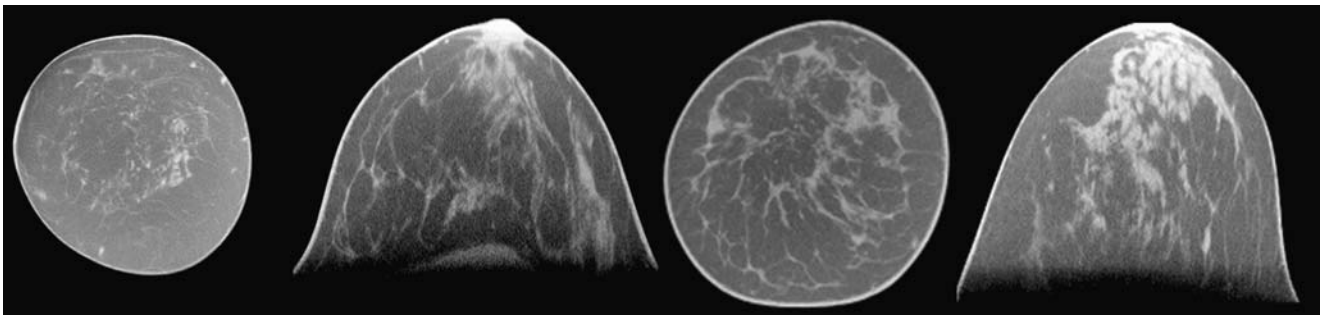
These four breast CT images were acquired from healthy volunteers. These images demonstrate anatomical detail not routinely seen in mammographic images.
